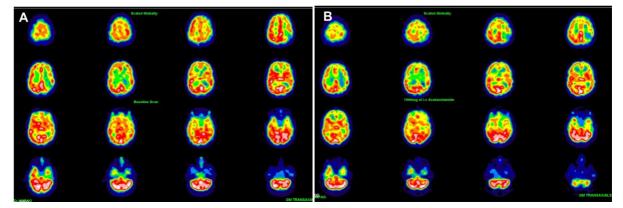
Postop SPECT with and without acetazolamide at 2 years showed improved haemodynamic response to acetazolamide.
